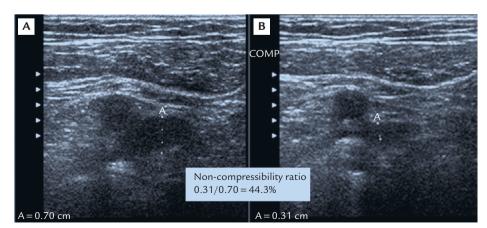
Non-compressibility ratio of thrombosed vein by transverse compression sonography. (A) Vessel diameter before compression. (B) Vessel diameter after compression.
